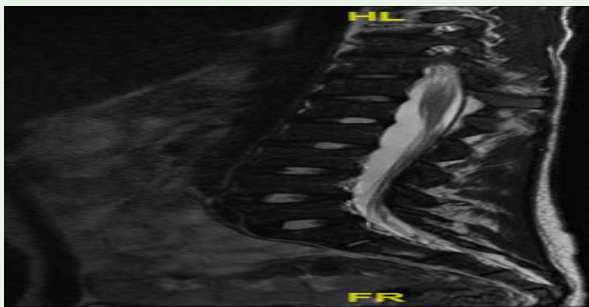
T2W MRI showing marrow infiltration and H shaped vertebra typical of SCD.
